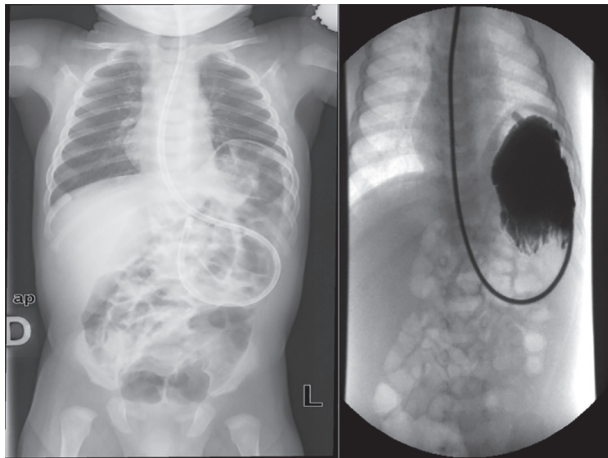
Plain abdominal X-ray and upper gastrointestinal contrast study showed an acute organoaxial gastric volvulus
